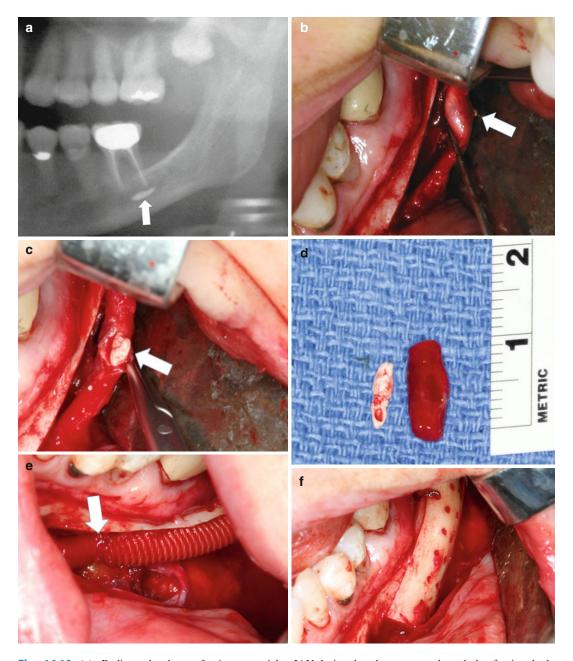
(a) Radiograph shows foreign material (*arrow*) in the IAN canal following root canal treatment resulting in a painful dysesthesia to the distribution of the IAN. (b) Following decortications of the mandible, the IAN has been lateralized from the mandible. The *arrow* points to the nerve lesion. (c) An incision into the nerve shows a foreign body within the nerve (*arrow*). (d) The
